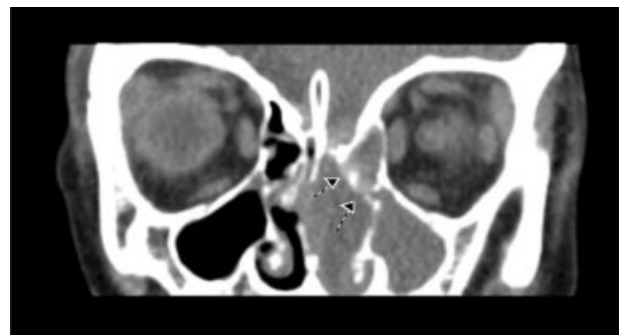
CT cisternogram, coronal view, demonstrates extravasation of radio-opaque tracer through left cribriform defect into left ethmoid region.
